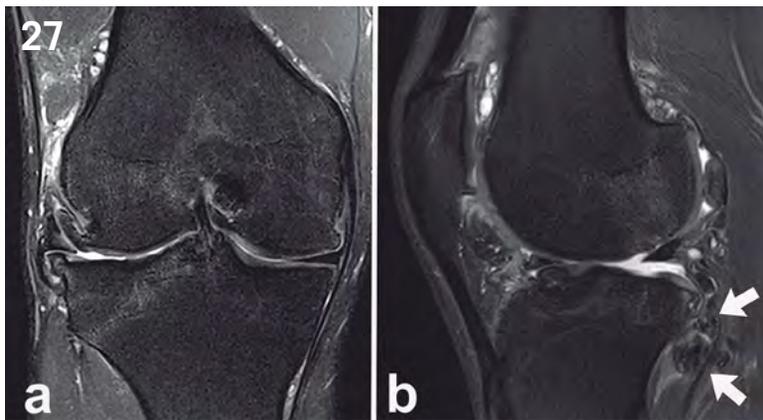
Osteoarthritis. 23 years-old asymptomatic male football player. (a) Coronal and (b) sagittal T2-weighted fat-suppressed MR images of the knee. Severe osteoarthritis in the patellofemoral and lateral femorotibial compartments, with diffuse and advanced chondral erosions, osteophytes, subchondral edema, degenerative meniscal tear with extrusion and loose bodies surrounding the popliteus muscle (arrows in b).
